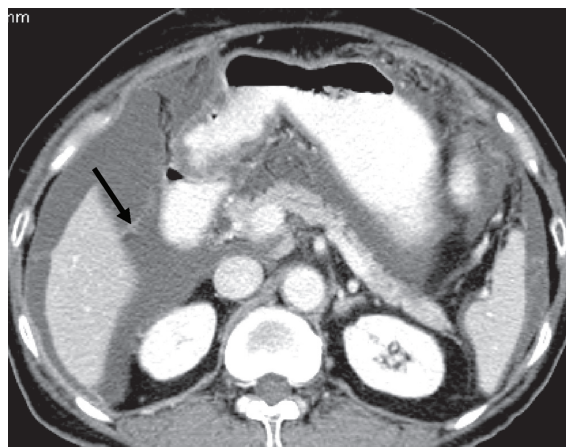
Axial image of contrast enhanced CT abdomen showed fibrin in ascites (arrow)
